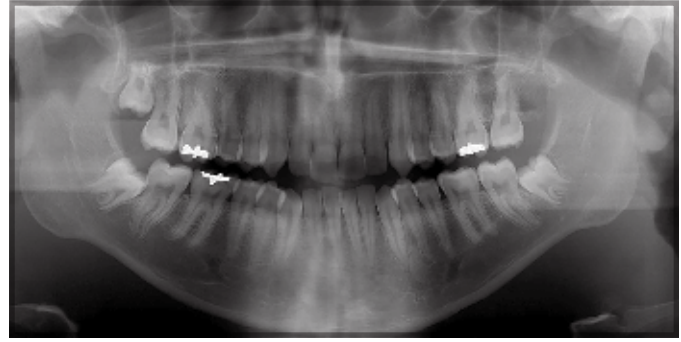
Case 2. Panoramic radiograph of a 17-year-old patient presenting for extraction of impacted molar teeth 1, 17, and 32.
